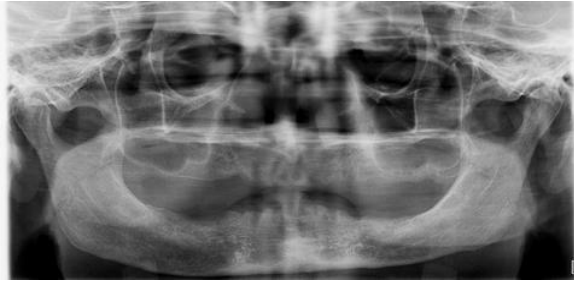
Orthopantomogram of the patient
